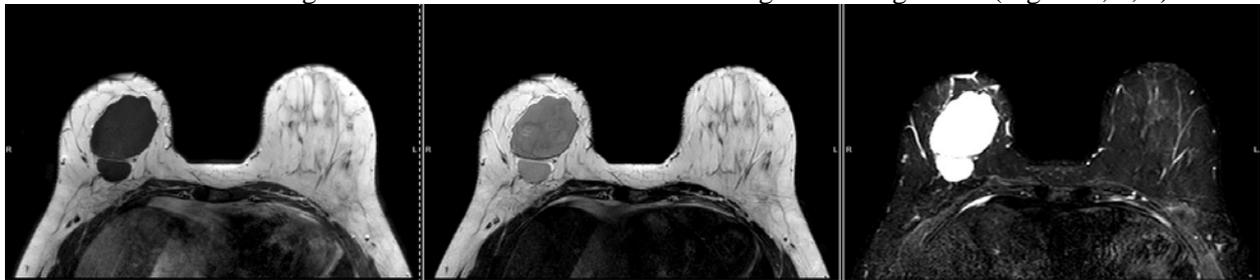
3T MRI - T1, T2 and STIR image suggesting the two adjacent breast masses.
